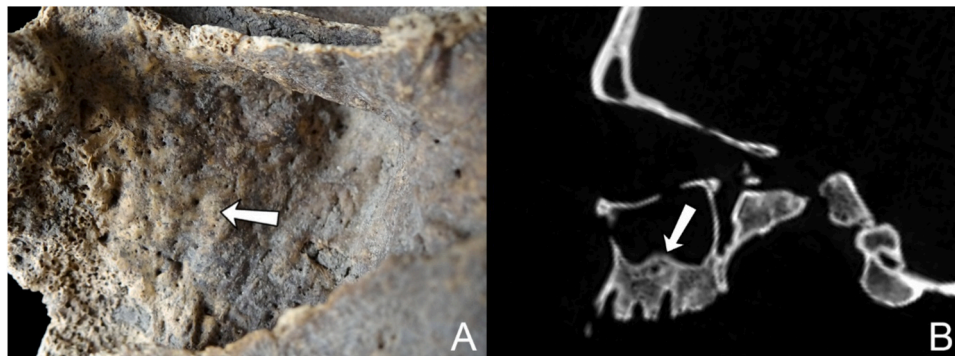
Examples of bone growth related to chronic maxillary sinusitis adapted from Boocock and colleagues (1995). Lesions are indicated by the white arrows. A) Macroscopic view of a broken sinus: thickening of the lateral wall; B) Radiographic view of an undamaged, enclosed sinus: bone formation in the form of thickening of the sinus floor.
